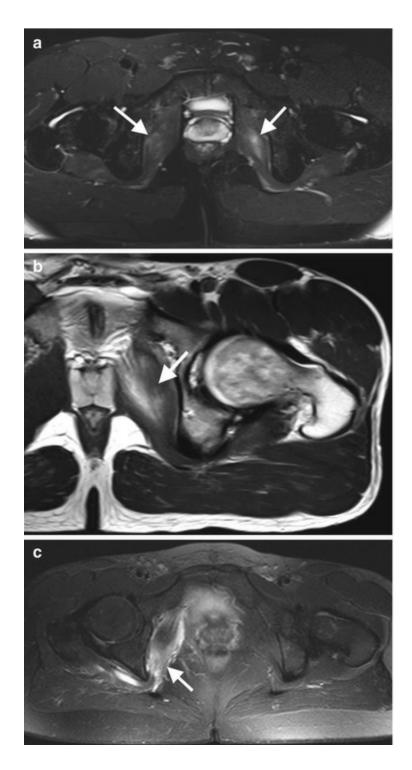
Traumatic injury to the internal obturator muscle. (a) A 20-year-old man. Axial fat-suppressed T2-weighted MRI shows bilateral partial tears of the internal obturator muscle (white arrow), slight on the right and more pronounced on the left. (b) A 22-year-old man. Axial T2-weighted MRI shows a partial central tear (white arrow) of the left internal obturator muscle. (c) A 27-year-old woman. Axial fat-suppressed T2-weighted MRI shows a pronounced partial tear (white arrow) of the superior right internal obturator muscle belly
